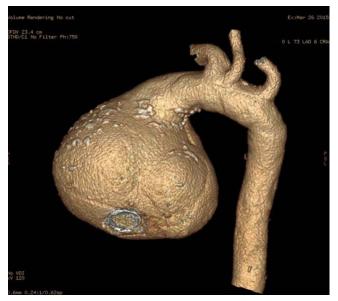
Preoperative 3D computed tomography scan reconstruction of the giant root aneurysm.
